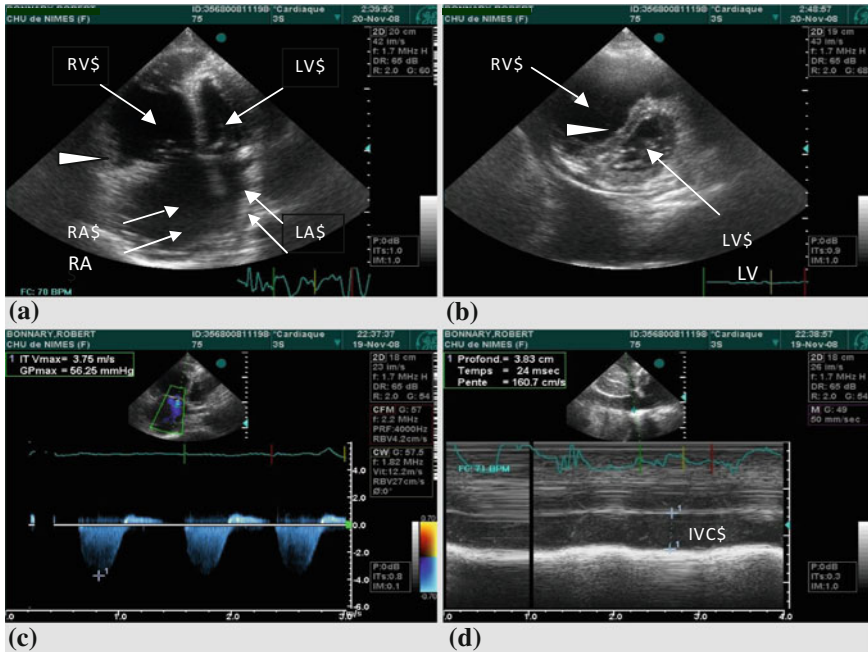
Echocardiography diagnosis of pulmonary hypertension. Idiopathic pulmonary arterial hypertension with chronic right ventricle failure in a 68 years-old patient admitted in ICU for septic shock in intensive care unit. a Four chambers apical view showing a major right atrial and ventricle (RV) dilation. The RV free wall is thickened (white triangle) due to a chronic adaptation to chronic pulmonary hypertension. b Parasternal short axis view. Paradoxical septum (white triangle) with typical left ventricle of “D sign”. In physiological condition, LV shape is circular (“O sign”). c Tricuspid regurgitation recoded by continuous Doppler. Maximal velocity (V_{max}) = 3.75 which correspond to a RV/PA gradient equal to 56 mm Hg ($\Delta P = 4 V^2$). d Recording of inferior vena cava (IVC) by M mode in a subcostal view. The IVC diameter is 38 mm and no respiratory variation is observed. The RAP value is over than 20 mm Hg (See Table 3). In this case, systolic pulmonary artery pressure is $56 + 20 = 76$ mm Hg. This was consistent with the value measured by pulmonary artery catheter (80 mm Hg)
